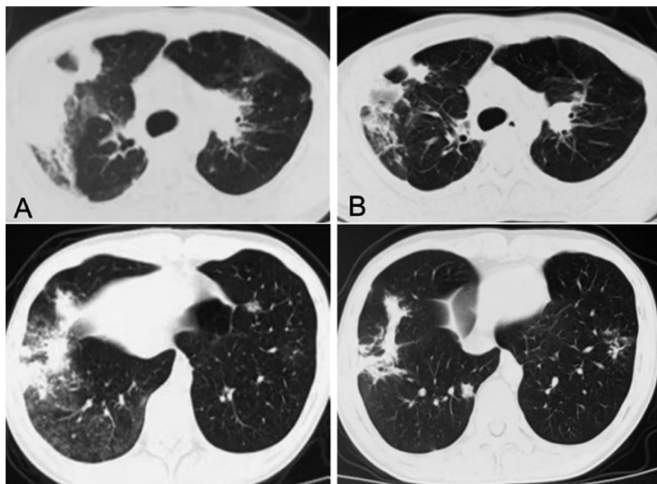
Comparison of chest CT after hormone withdrawal.
